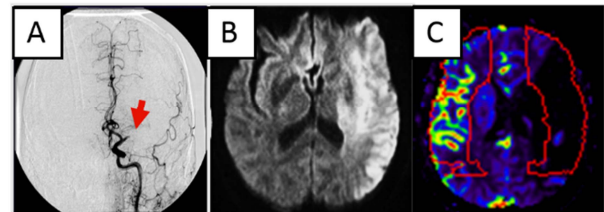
Angiogram, DWI, and perfusions images with generated ROI of superior branch of MCA
